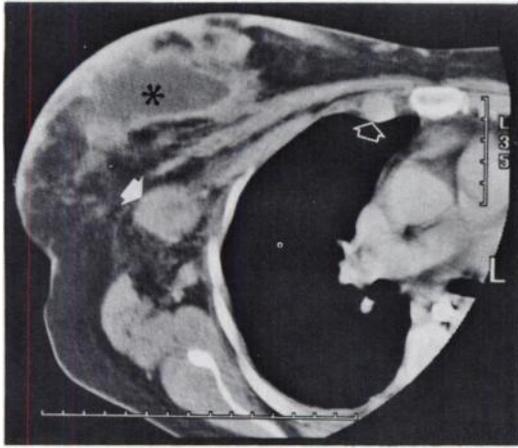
Transaxial CT image of right low chest shows a large mass with low attenuation center (*). Note enlarged right axillary (closed arrow) and internal mammary lymph nodes (open arrow).
